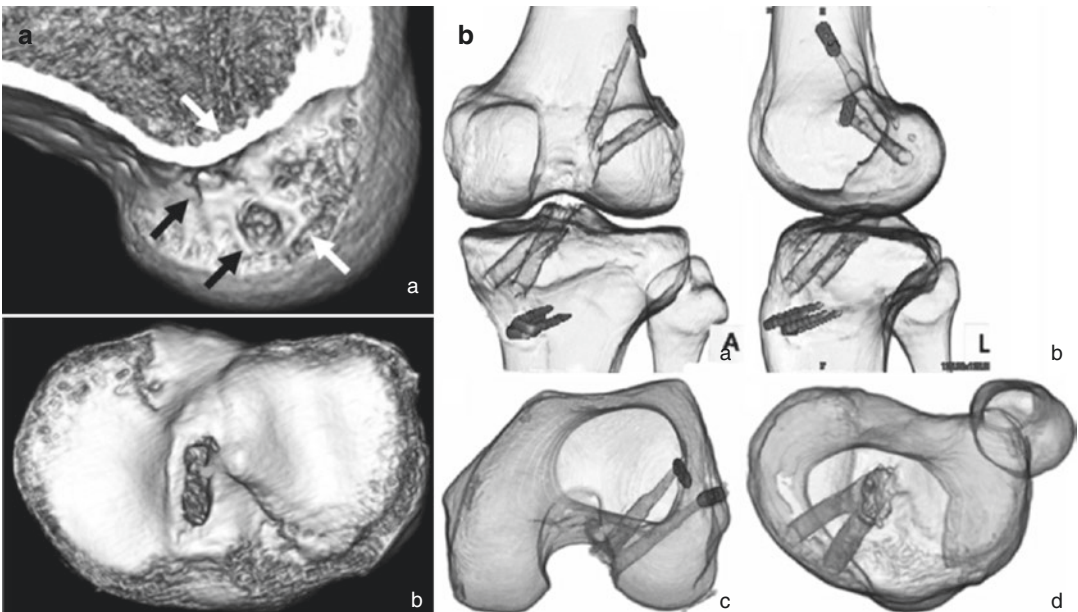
The anatomical femoral tunnel outlets created for anatomic DB reconstruction with the TT technique (a) (From [51] with permission). Transparent 3D CT images
